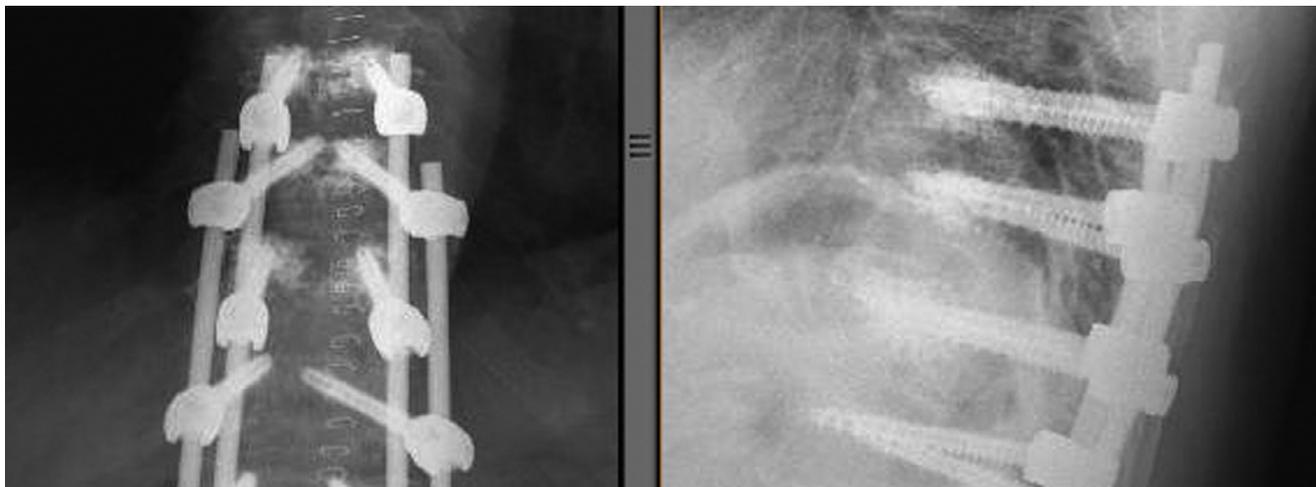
Cement augmentation using fenestrated pedicle screws. AP and lateral X-ray.
